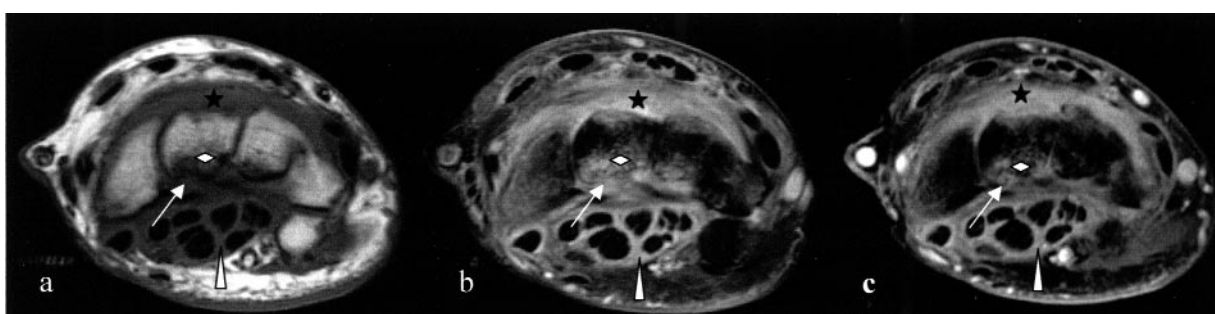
Axial MRI examination of the left wrist in a 39-year-old patient with psoriatic arthritis. Synovitis (★), bone marrow edema in the synovial site (↖), and tenosynovitis (↗) are visible on axial SE T1-weighted (a), FS T1-weighted post-contrast (b), and FS T2-weighted images (c). Erosion localized in the synovial site of the caputatum (↗).
